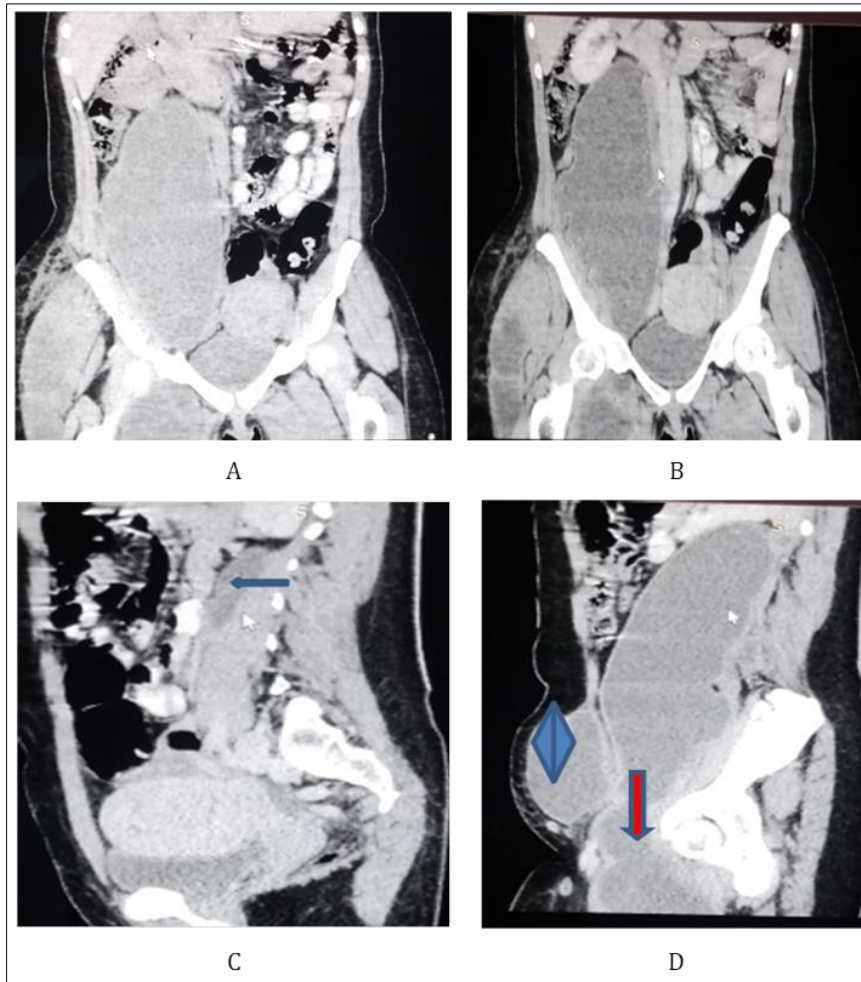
b and 4c-d are coronal and sagittal reformatted non-contrast and contrast enhanced CT scan images respectively. They also showed the abscess/collections with its extension from the abdomen into the pelvic (red arrow-image d), gluteal region and the subcutaneous /flank region (doubled edged blue arrow-image d) respectively. Image c is showing the left psoas muscle collection/abscess (blue slimmed body arrow)
